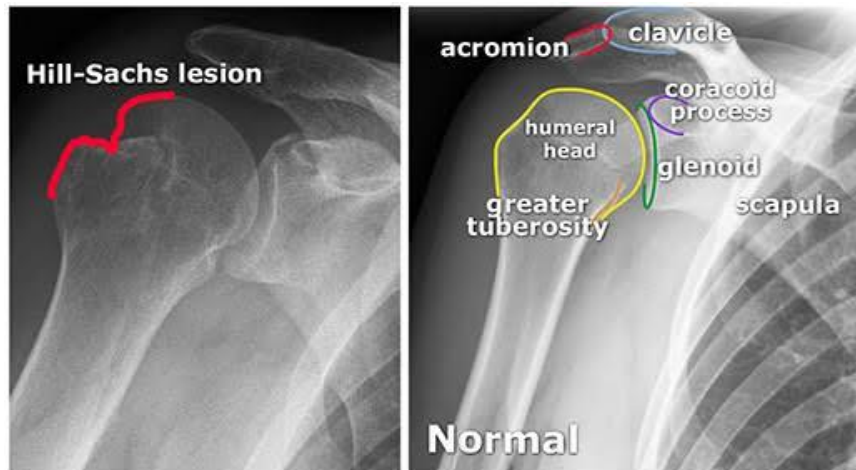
Antero-posterior x-rays reveals a Hill-Sachs lesion compared to normal anatomy.¹⁰
